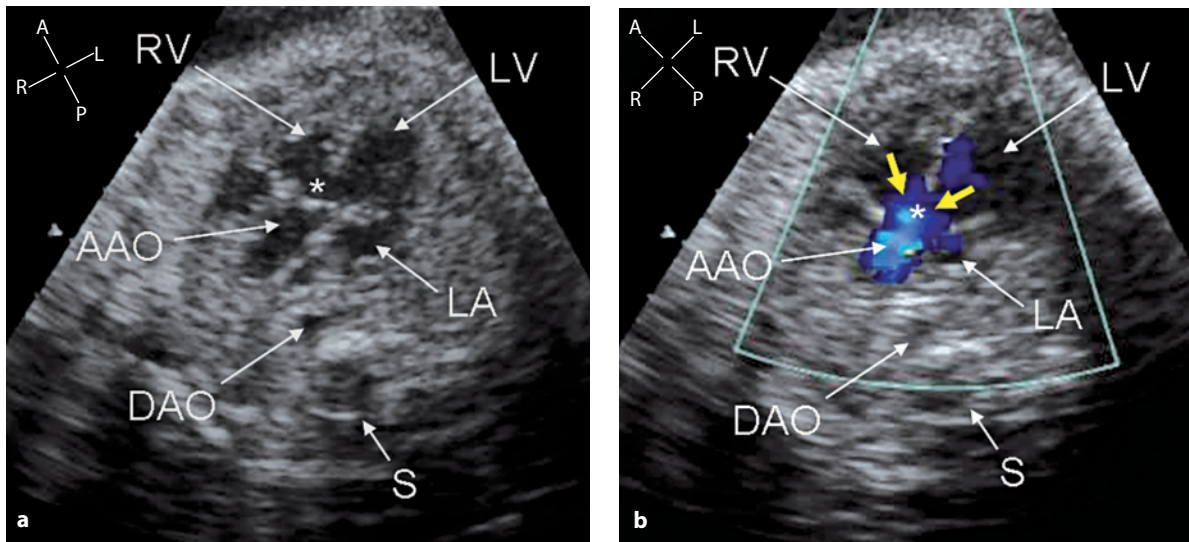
• A 35-week gestational-age fetus with obstruction of the left ventricular outflow tract due to a single tumor of the interventricular septum (*yellow asterisk*). This cross-sectional image (a) shows a circumscribed tumor of the ventricular septum extending from the midtrabecular portion to the subaortic region. The mass appears homogeneous and slightly more echogenic than the surrounding myocardium. The tumor is protruding to the left, narrowing the lumen of the left ventricular outflow tract. Despite the size of the tumor and the reduced size of the left ventricular outflow tract, the outflow of the left ventricle shows unaltered flow (b). Pulsed Doppler tracing (c) of the left ventricular outflow in the same patient, with the sample volume positioned just at the level of the aortic valve. The Doppler spectrum shows a peak velocity of 79 cm/s, within the normal ranges. *AAO* ascending aorta, *DAO* descending aorta, *LV* left ventricle, *LVOT* left ventricular outflow tract, *RA* right atrium, *RV* right ventricle, *S* spine
